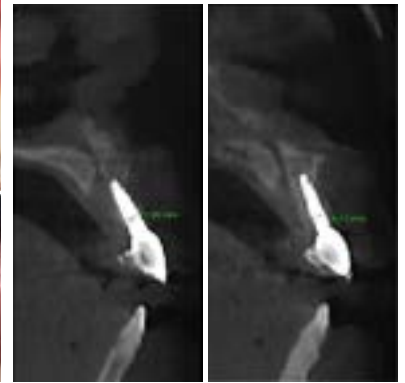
Cone beam computed tomography after 10 months of surgery.
